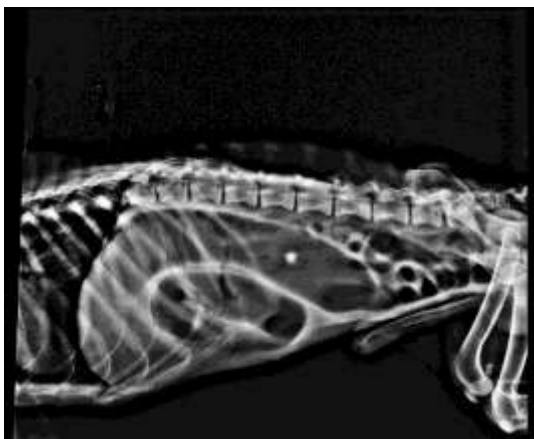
Plain radiograph showing dilated gas filled intestinal loops (white dot in the descending colon is an artifact)
